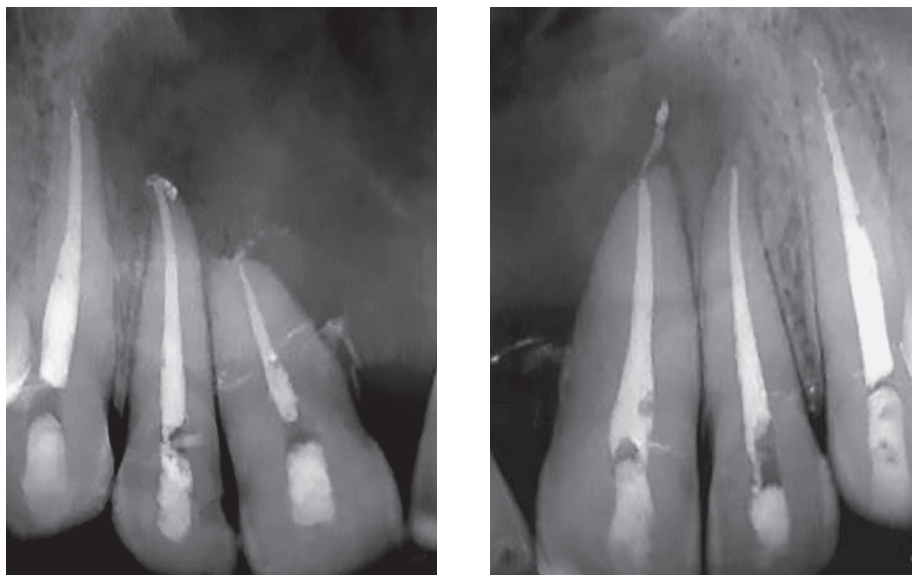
Radiographic images of teeth after treatment.
